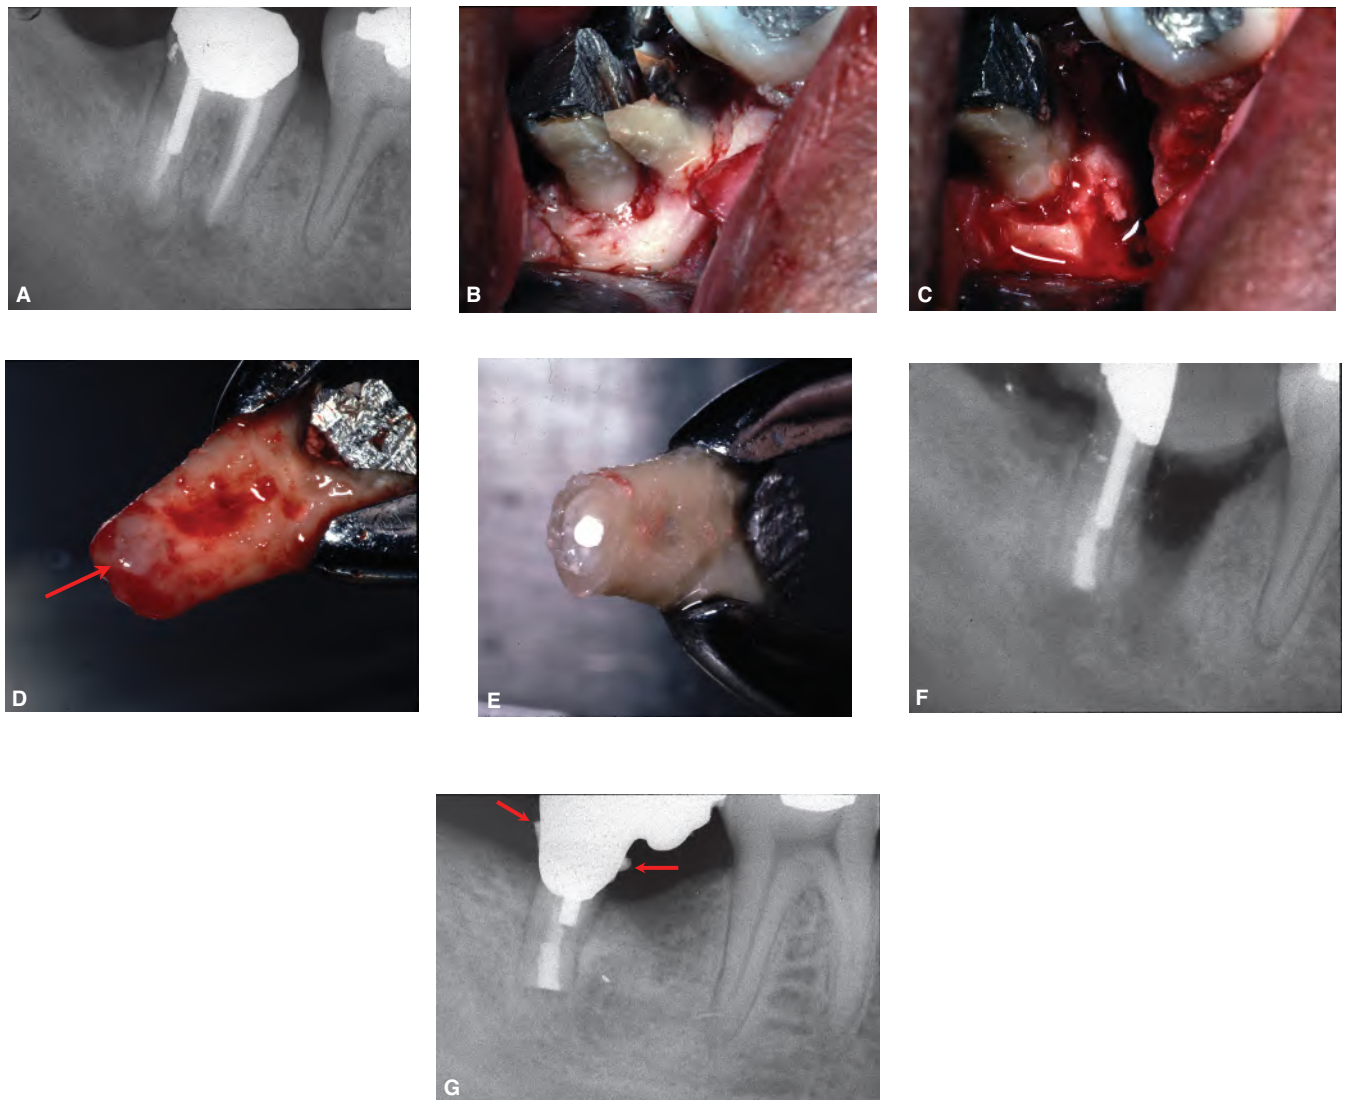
Salvaged root fracture in a mandibular right second molar. A. Preoperative radiograph. Note the large post in the distal canal, the convergence of the root forms and periapical areas on both root apices. The tooth has an amalgam buildup, and a temporary crown is in place. B. The mesial aspect of the root has fractured during the extraction, and the tooth has been hemisected through the furcation. The convergence of the mesial and distal roots is the most likely reason why the tooth was resistant to extraction and fractured. C. The mesial root has been atraumatically extracted, with minimal buccal cortical plate involvement. D. The distal root apex prior to resection. Note the small lesion attached to the root (arrow); it will be removed with the resected root tip. E. The distal root-end has been resected, and the root-end filling (Super EBA) has been placed and finished. F. Immediate postoperative radiograph. The distal root has been replanted, and the temporary crown relined and provisionally cemented over the root. Stabilization was achieved by bonding the temporary crown to the lingual of adjacent first molar, using orthodontic bonding resin. A small mylar plastic strip was placed over the exposed mesial extraction socket during the reline procedure to prevent migration of the acrylic into the socket. G. Eight-year recall radiograph. The area healed and periodontal probing depths were normal, in spite of the presence of deposits (arrows) on the abutment crown of this inlay mini-bridge.
